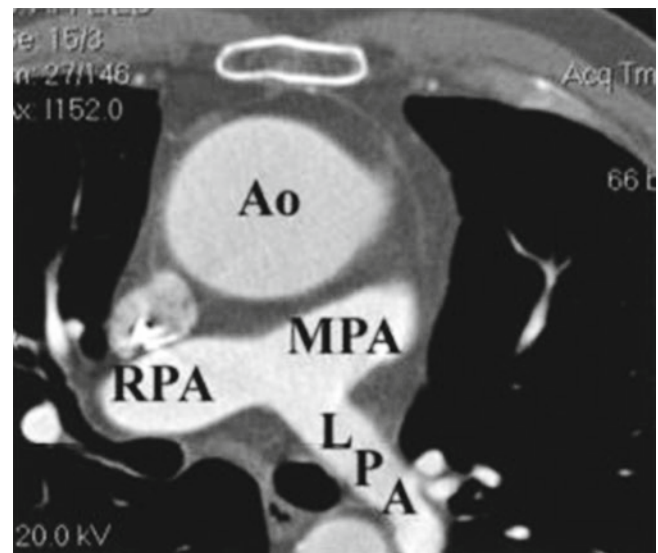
A 16-slice CT angiogram is shown of a 61-year-old man with Marfan syndrome, a chronic Stanford type B dissection, and a mechanical mitral valve prosthesis. (a) Axial cut at the level of the aortic arch, demonstrating a dissection flap starting at the distal arch; FL
